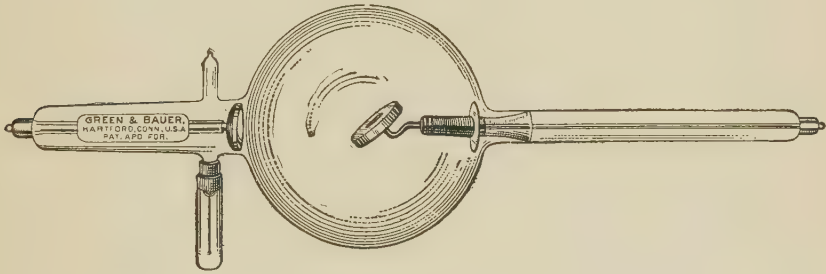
Roentgen Ray Tube with Heavy Platinum Anode, for Coils.
